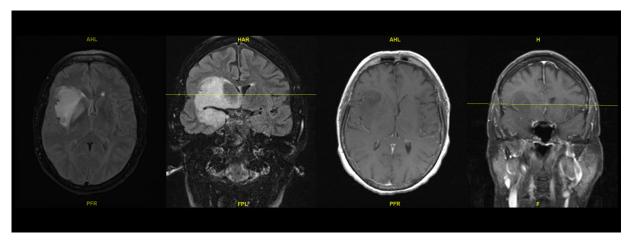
Brain MRI with T1 postcontrast (axial/coronal) and FLAIR (axial/coronal) showing expansile signal abnormality in the anteromedial right temporal lobe with associated involvement of the frontal operculum and gangliocapsular structures.
